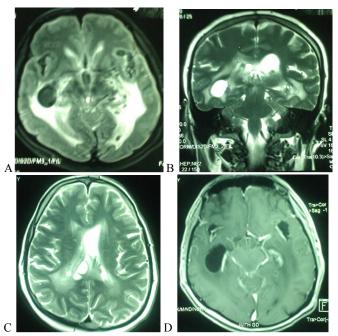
Imaging study: Extensive periventricular lesions and multiple cystic changes, were detected on FLAIR (A) and T2W (B, C) brain image. MRI with Gadolinium (D) enclosed significant ventricular and basal cisterna enhancement despite of antifungal treatment. Above findings were in favor of persistent infectious inflammatory reaction.
